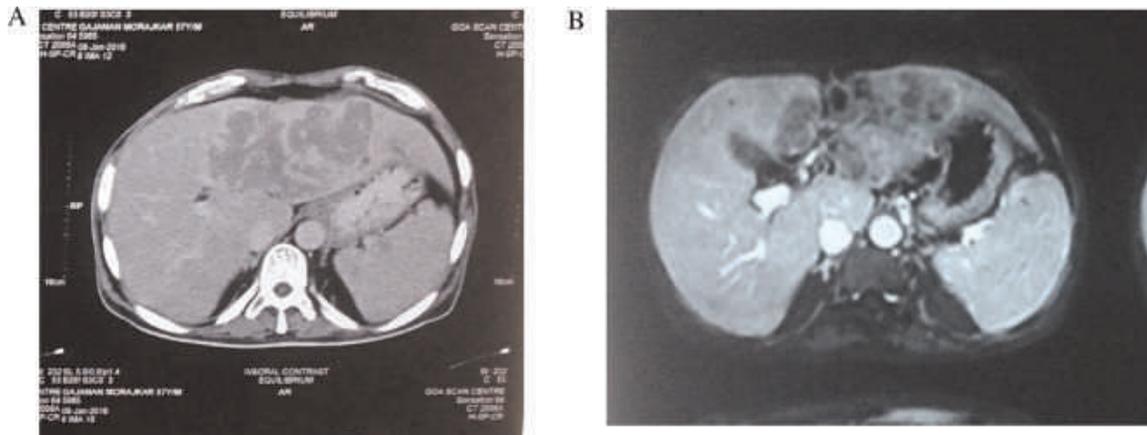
(A) CECT Abdomen showing a Nonenhancing mass 11×7 cm with slightly enhancing peripheral rim involving almost entire left lobe of liver mainly segments II, III, IV. As can be seen splenic parenchyma is not involved. (B) Magnetic resonance imaging (MRI) abdomen showing a hypointense mass with a hypointense rim in left lobe of liver on T1-weighted imaging.
